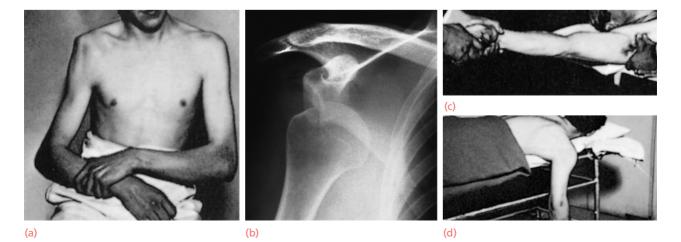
Anterior dislocation of the shoulder (a) The prominent acromion process and flattening of the contour over the deltoid are typical signs. (b) X-rays confirm the diagnosis of anterior dislocation. (c,d) Two methods of reduction.
